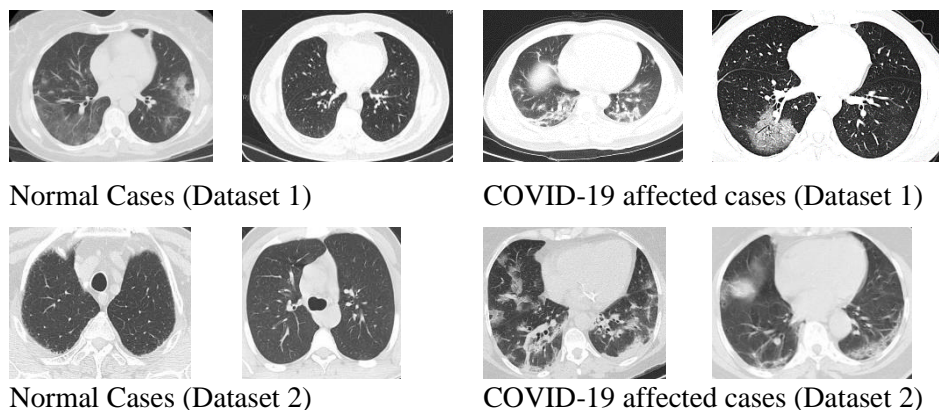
Sample CT images from Dataset 1 [34] and Dataset 2 [35]
